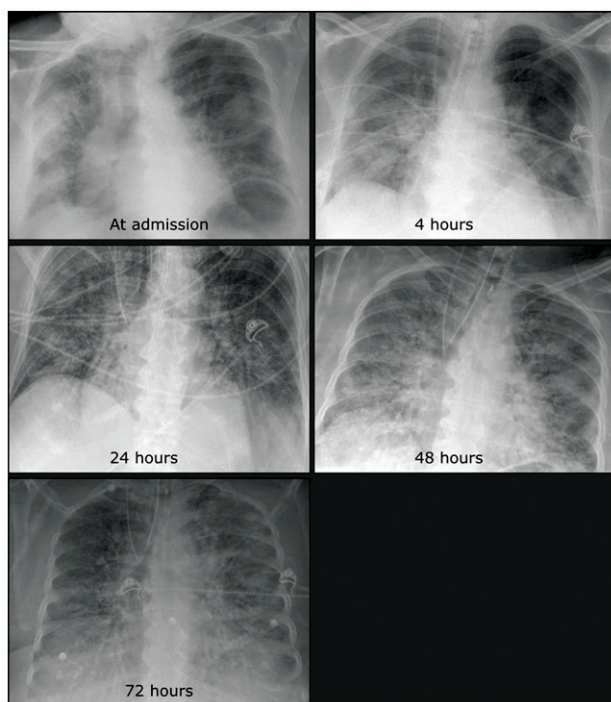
Serial Chest Radiographs of COVID-19 Patients
